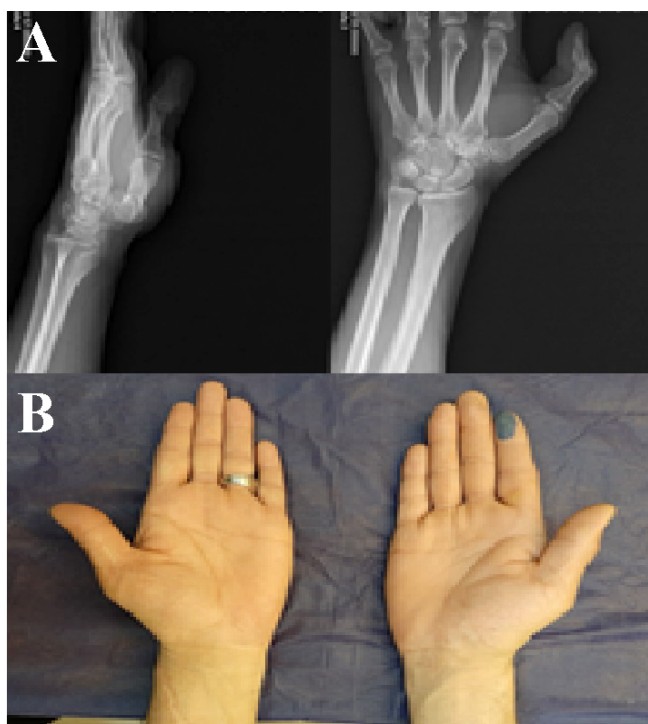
A. hand X-ray showing no bony lesion or pathologies B. As seen in the left-hand photography, there is a lumping mass on the ulnar side of the wrist.
